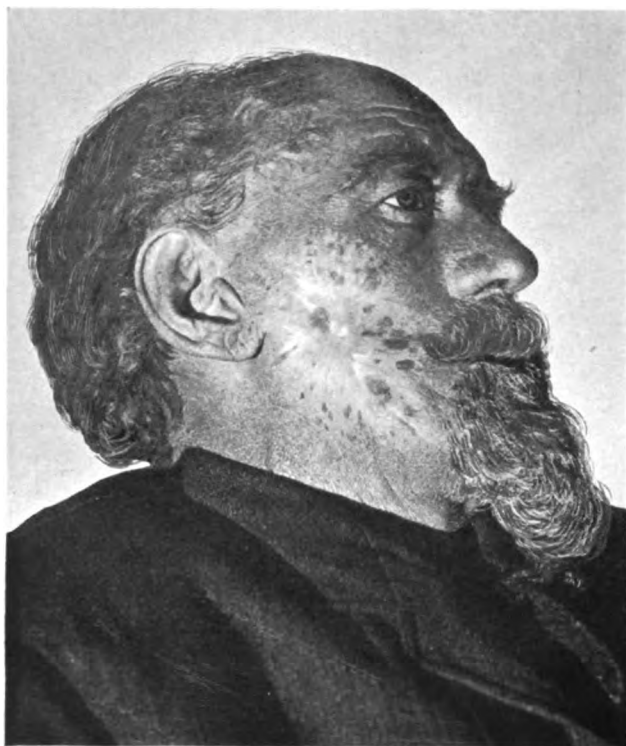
Result of x-ray treatment of patient shown in Figs. 46 and 47, 3 years after x-ray treatment was discontinued.
